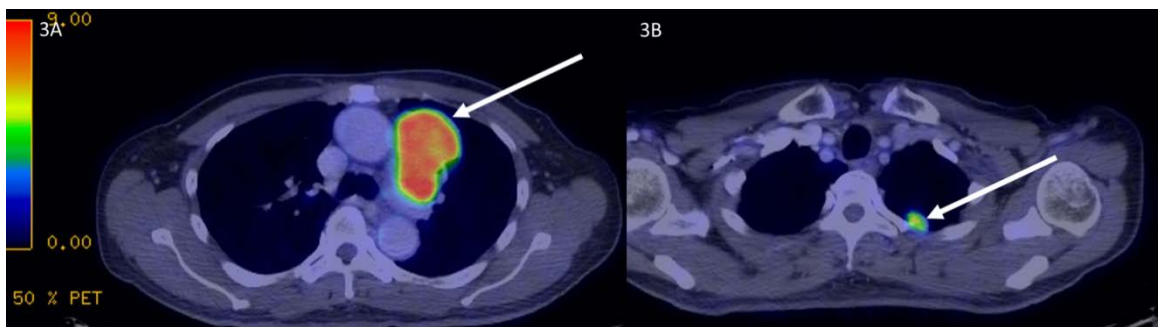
FDG PET-CT axial sequences demonstrating (white arrows) the intensely FDG avid mass in the region of anterior mediastinum (3A) and mildly FDG avid left pleural nodule (3B). *TECHNIQUE:* 7.5 mCi of F-18 Fluorodeoxyglucose; CT – 100.0 kV; Slice thickness – 3.75 mm.
